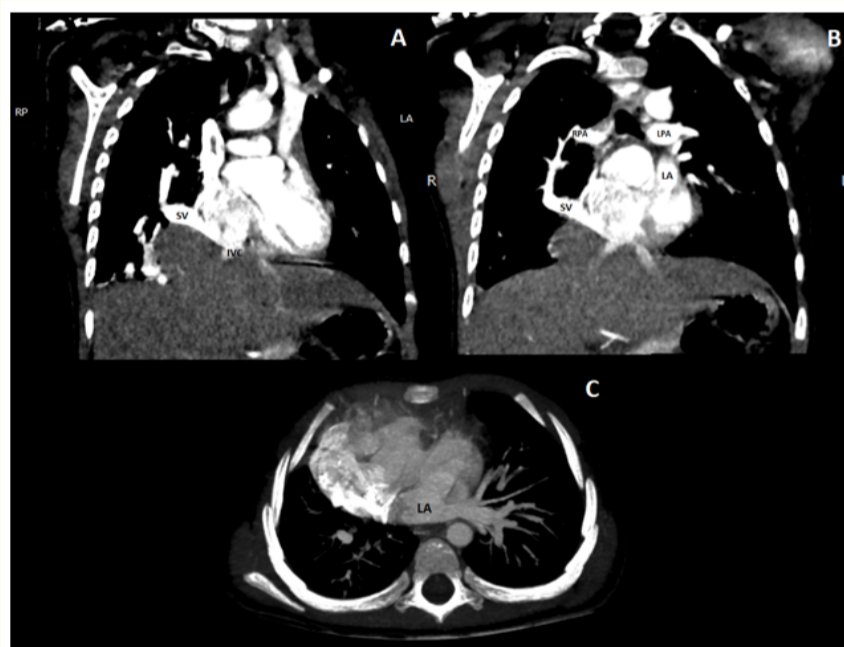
Chest angio-CT, (A) and (B): Coronal sections showing an abnormal right pulmonary venous drainage through a descending vein connected to the inferior cavoatrial junction; (C): Axial section showing a normal left pulmonary venous drainage into the left atrium *LA: left atrium; RPA: right pulmonary artery; LPA: Left pulmonary artery; SV: scimitar vein; IVC: inferior vena cava.
